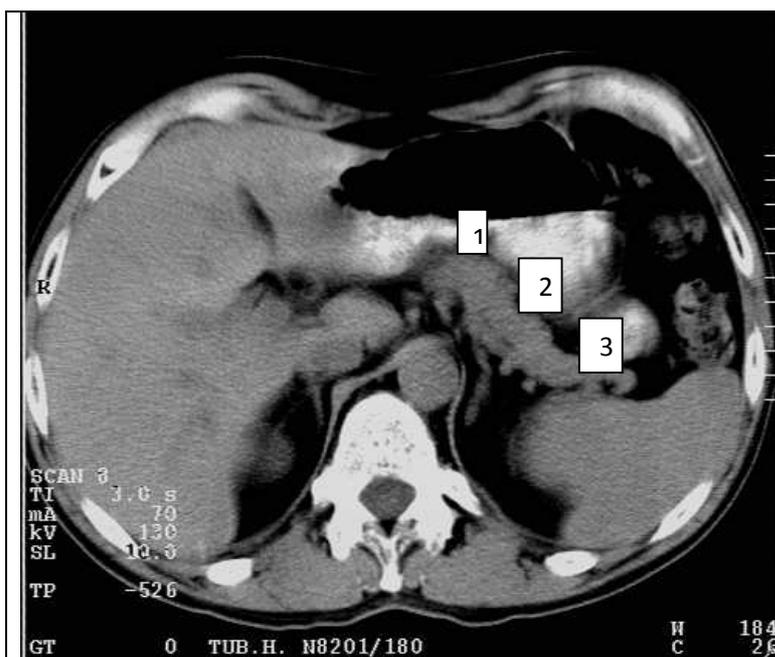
CT-scan pancreas in norm
